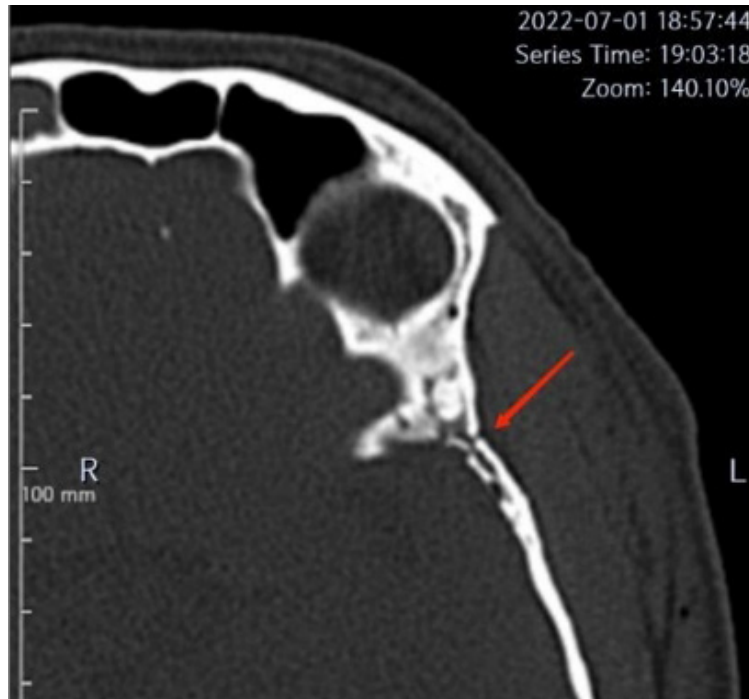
Non-contrast head CT scan from July 1, 2022. Arrow indicates the suspected fracture site
